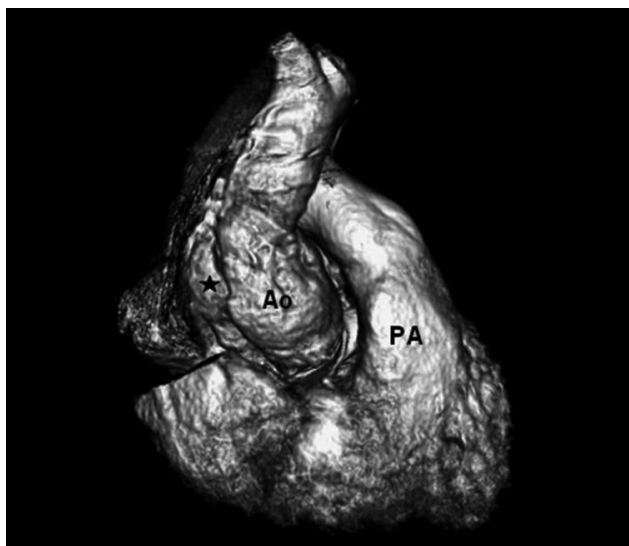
Multislice computed tomography depicting a pseudoaneurysm of the aorta (*). PA indicates pulmonary artery; Ao, ascending aorta.
